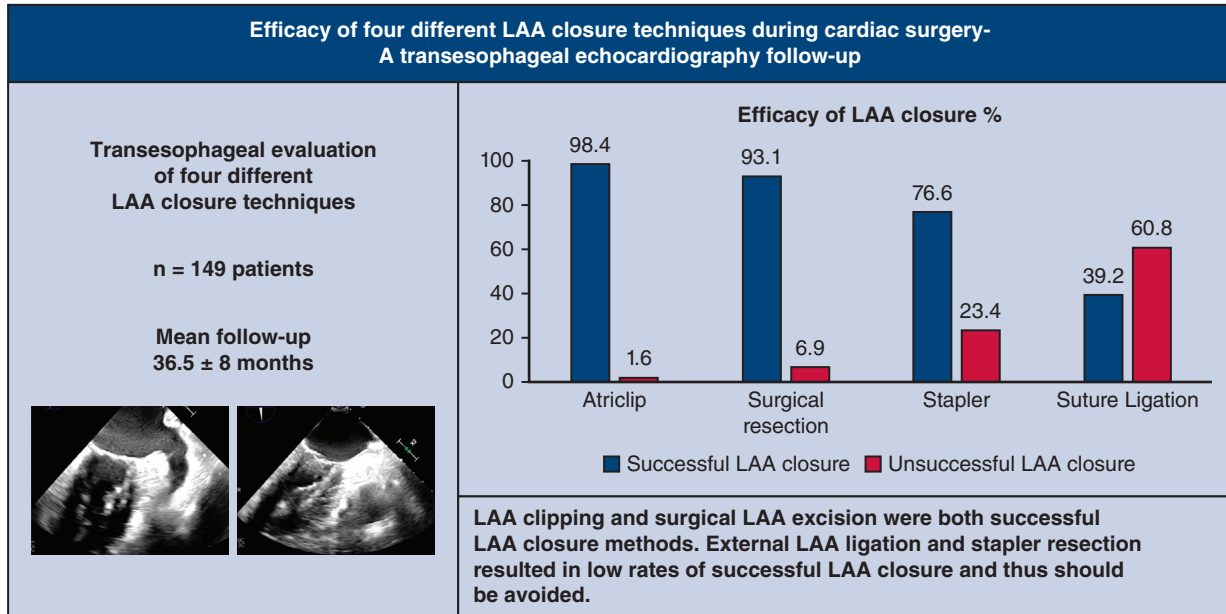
In this study, transesophageal echocardiography was used to evaluate success of four different LAA closure techniques with a mean follow-up of 36.5 months. LAA clipping and LAA excision were both successful LAA closure methods with success rates of 98.4% and 93.1%, respectively. External LAA ligation and stapler resection resulted in low rates of successful LAA closure. *LAA*, Left atrial appendage.
